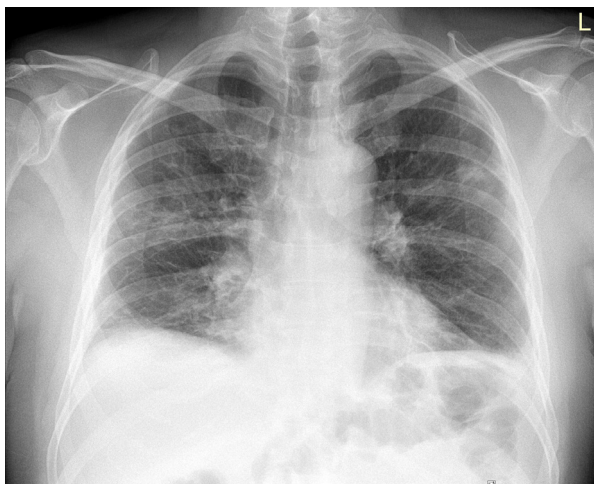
Chest X-ray on hospital admission (day 0)
